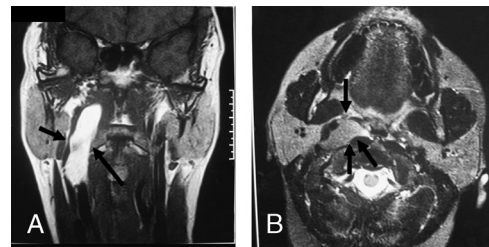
The retropharyngeal lipoma on coronal T1 MRI image (A) and axial fat-suppressed image (B) in 2009 (arrows).
